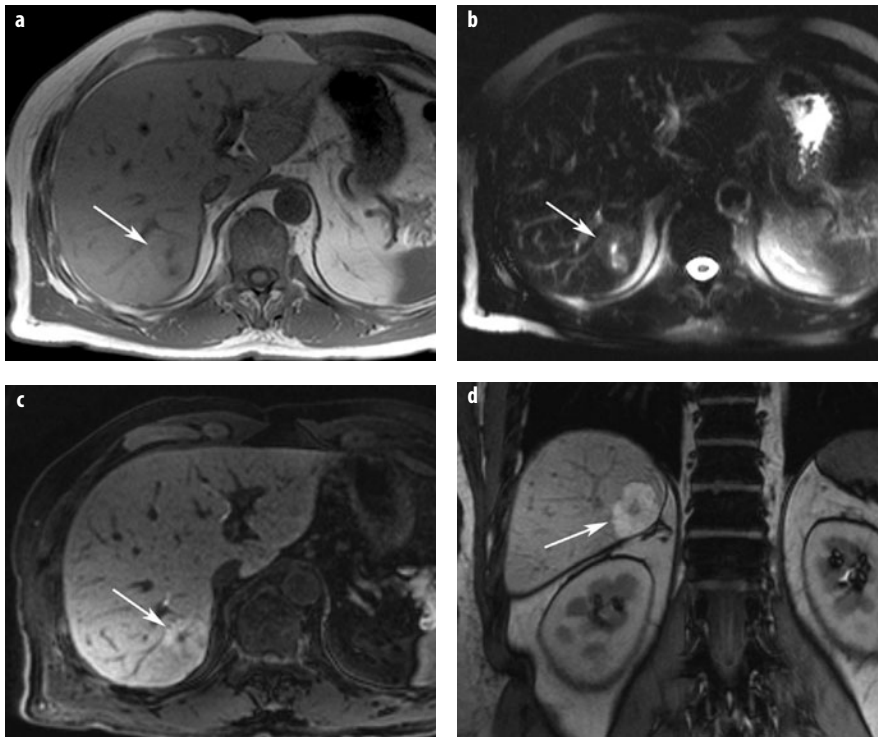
a-d. Focal nodular hyperplasia (FNH). a The lesion (*arrow*) is isointense on T1-weighted image and shows a small central scar. b On T2-weighted images, the lesions is also isointense (*arrow*), the central T2-weighted bright scar is better discernible. c, d T1-weighted images with liver-specific contrast agent in axial and coronal planes show homogenous uptake of the liver-specific agent, typical for FNH (*arrow*). The central spoke-wheel scar is nicely depicted
